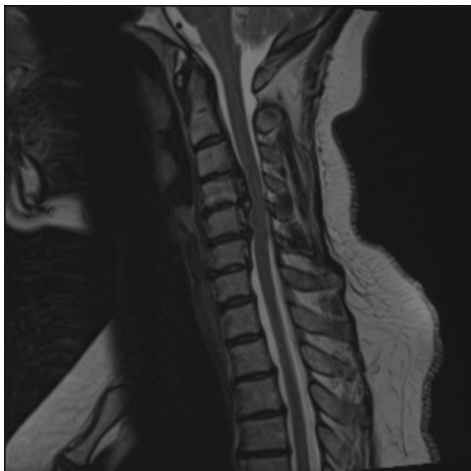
Preoperative midline sagittal T2-weighted MR of C3-C4 to C5-C6 OPLL. This study confirmed the massive ventral OPLL C3-C6 and the resultant increased cord signal extending from above the C3-C4 level down to the mid C5 level. Further, the inhomogeneous, signal within the OPLL mass reflected active bone marrow production occurring in Haversian canals. This study also showed the negative K sign (vertical line between midpoint C2 to mid-point C7) indicating that a direct anterior approach to OPLL was warranted.
